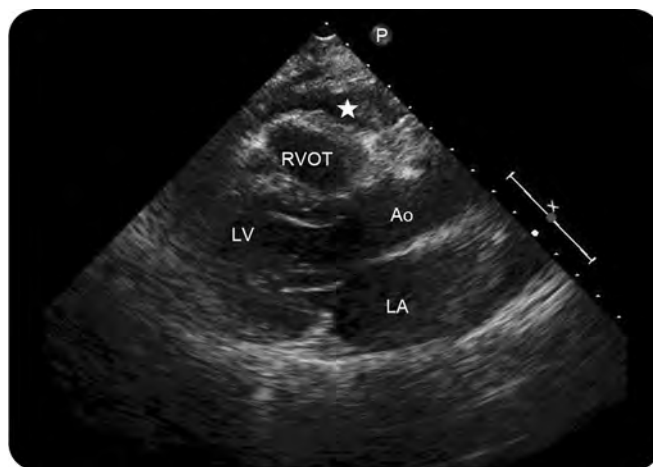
Transthoracic echocardiography in parasternal long-axis view shows epicardial fat (white asterick) as hypoechoic anterior echo-free space anterior to RVOT
